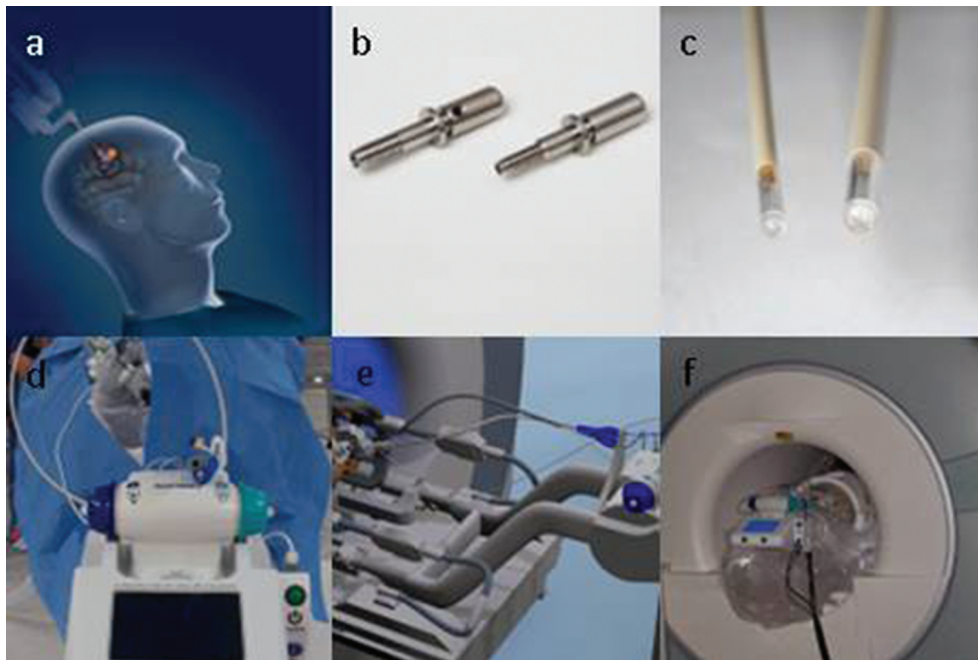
(a–d) show the individual components of NeuroBlate® System including the bolts (b), laser probes (c) and robotic motor drive (d). Figures 1e–f depict the integration of robotic motor drive with the MRI scanner. (Images used by permission from Monteris Medical Corporation, Plymouth, MN, USA. The use of any Monteris Medical photo or image does not imply Monteris' review or endorsement of any article or publication).
